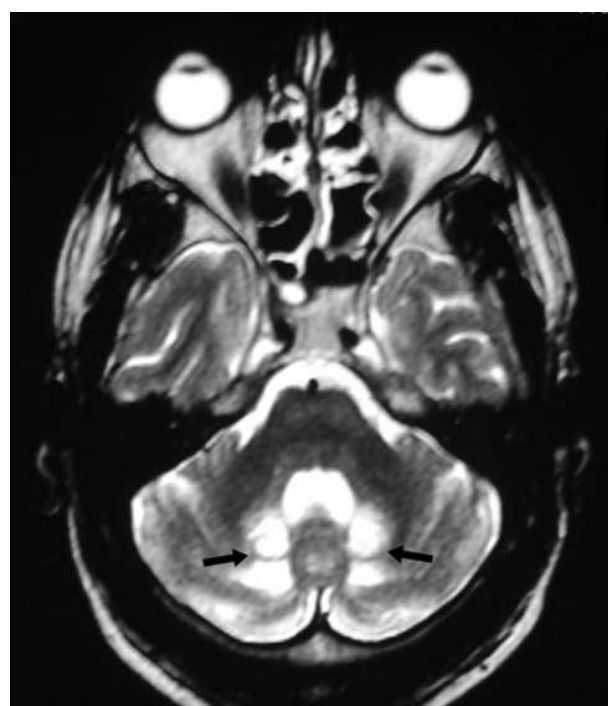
Peridentate region T2 hyperintensity. Brain MRI of a CTX patient showing increased T2 signal within the dentate nuclei and the surrounding white matter bilaterally (arrows).
